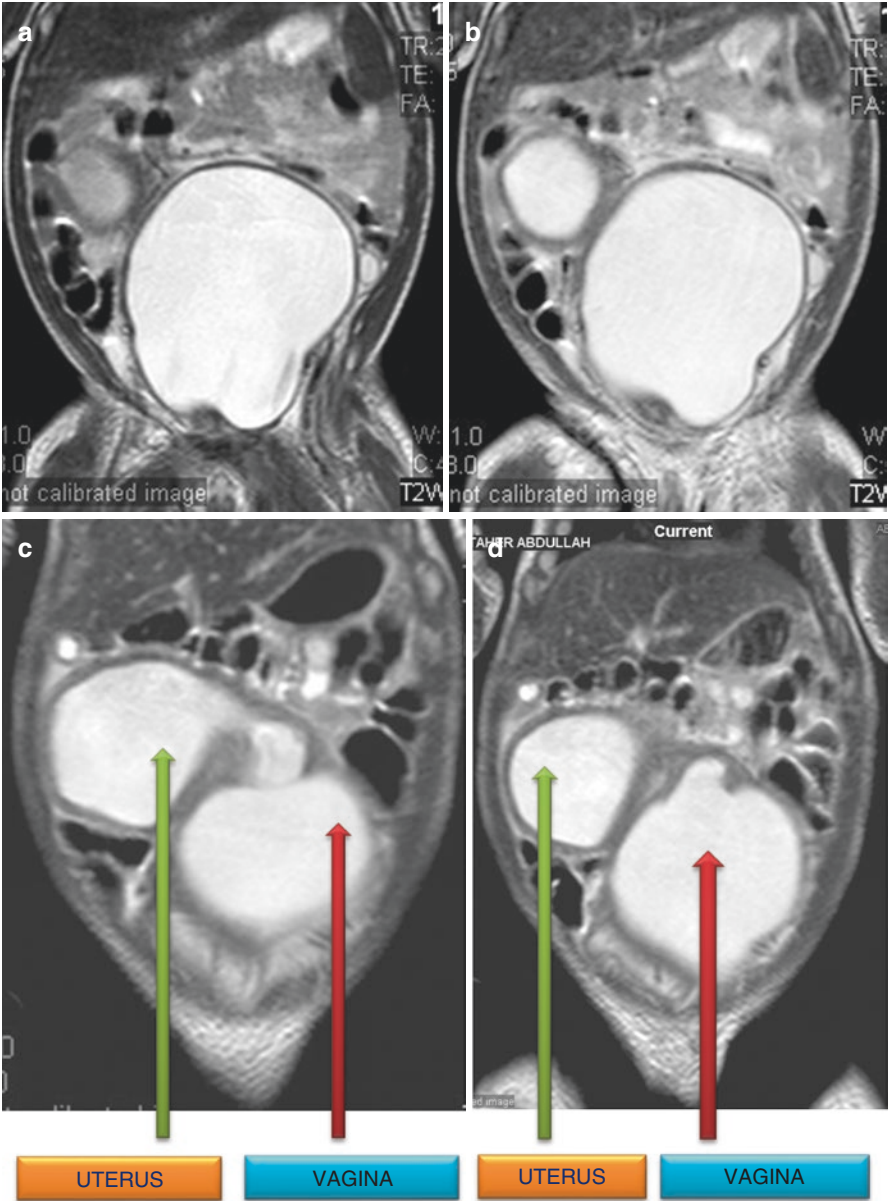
(a–h) MRI showing hydrometrocolpos. Note the markedly dilated vagia and uterus. Note also the level of vaginal atresia
